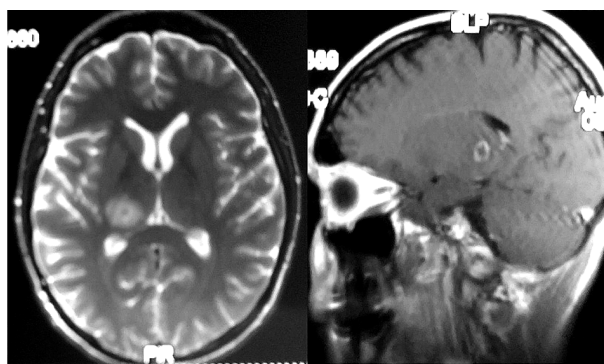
Focus of the brain demyelination on MR imaging a week before admission
